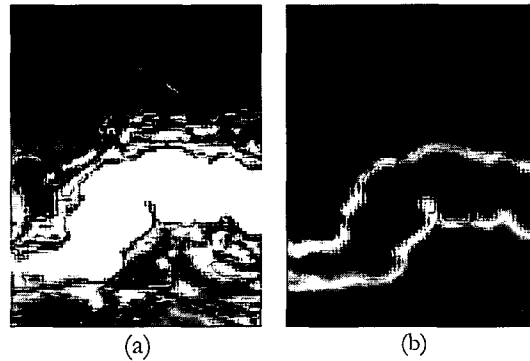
(a) Part of a slice in an MRI volume and (b) the result of the PLUS operator.
